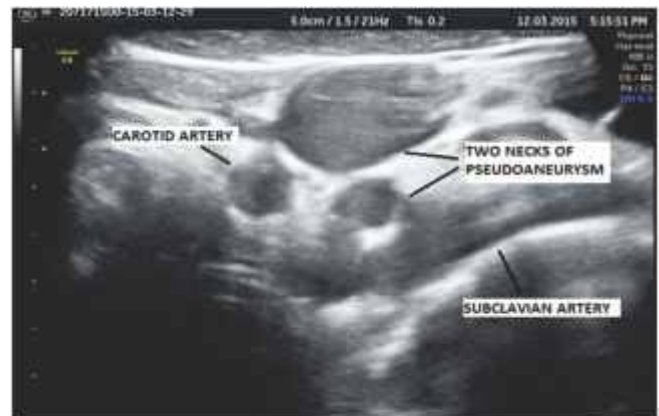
Gray-scale Ultrasound demonstrates two hypoechoic cystic structures adjacent to the donor subclavian artery supplying the pseudoaneurysm.
